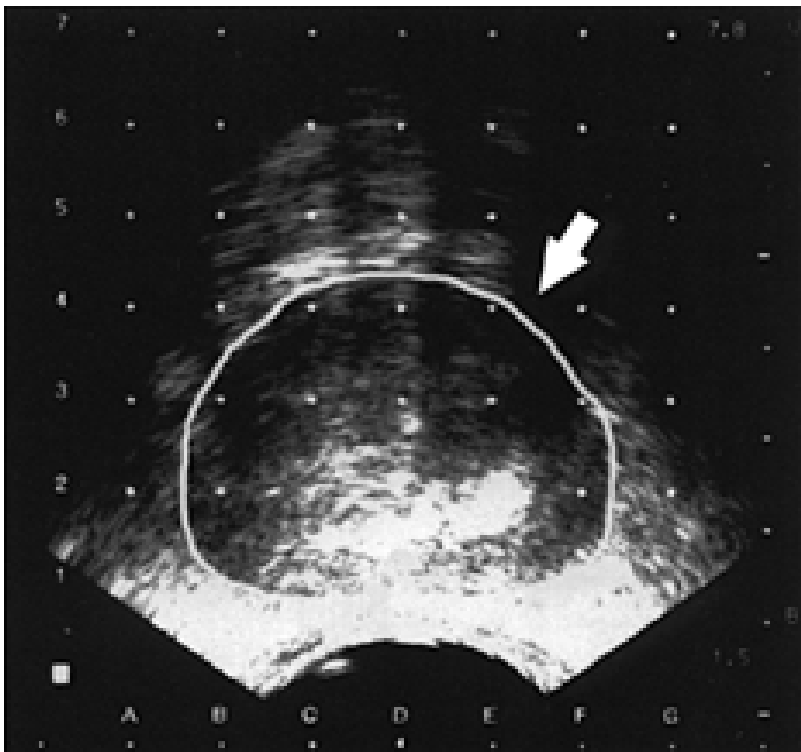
Transfers ultrasound image of prostate (*arrow* points to outline) in which the electronic grid is superimposed. This image corresponds to that of the needle-guiding template. (From Pais VM, Focht T, Canaday DJ, et al. Brachytherapy for prostate cancer. *Infect Urol* 2000;May/June:59, with permission.)
